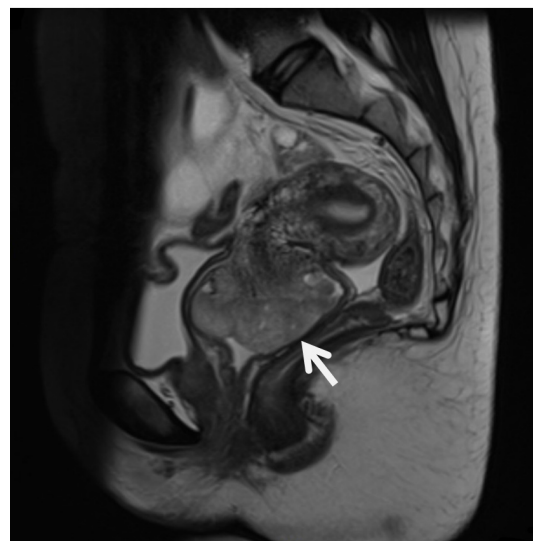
T2 weighted magnetic resonance imaging of the pelvis showing the 5.7 cm x 4.6 cm cervical cancer mass (white arrow) causing distension of the upper vagina but no extension to the uterus.
